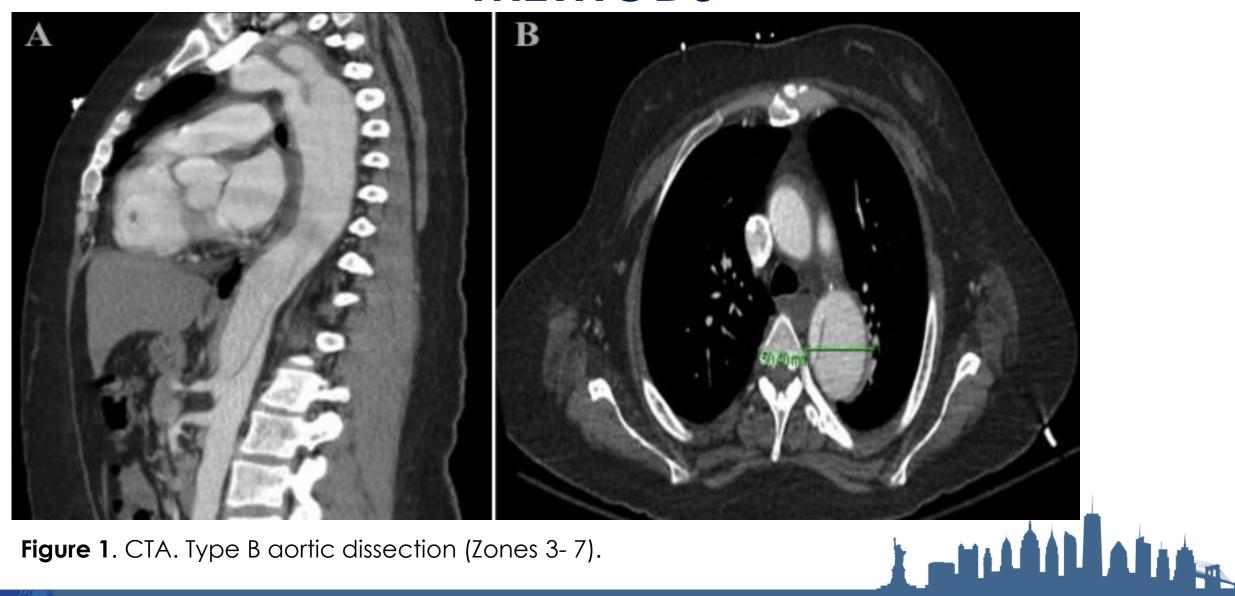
CTA. Type B aortic dissection (Zones 3-7).
